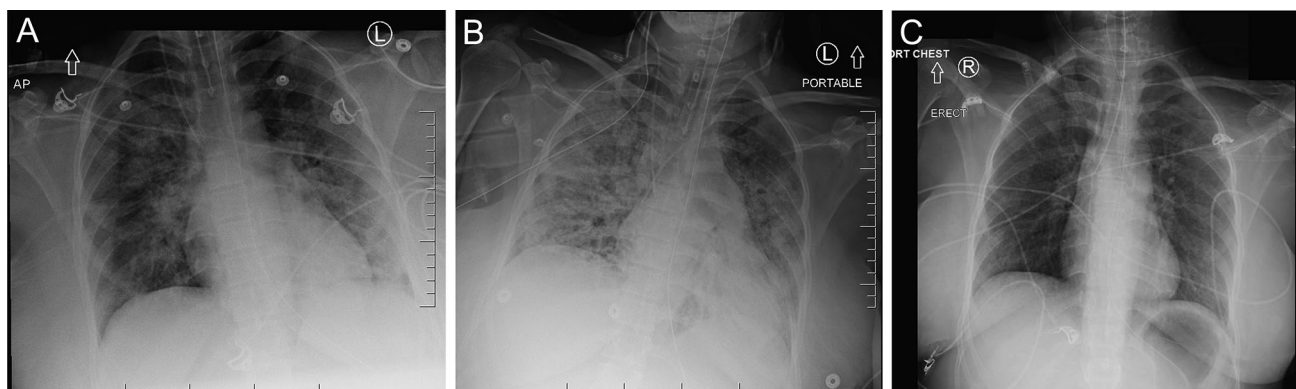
Figure Chest *x-ray*. A) Day 1 of admission. Significant bilateral pulmonary opacification, in keeping with COVID-19 pneumonia. Blunting of the left costophrenic angle with no large pleural effusion present. B) Day 14 of admission. Pre-Cesarean delivery chest *x-ray*. Increasing bilateral opacities associated with presumptive diagnosis
